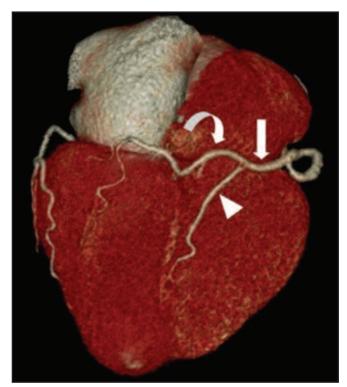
Inferior view of a 3D volume-rendered CT angiography showing a right dominant coronary circulation that refer to the RCA (arrow) and divides into the PDA (arrowhead) and the PLB (curved arrow).
